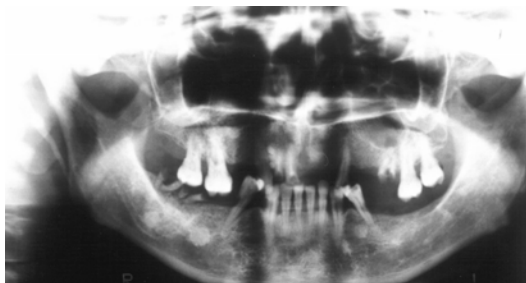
Multiple mandibular osteomas seen on orthopantomography in a 24 year old male FAP patient.
